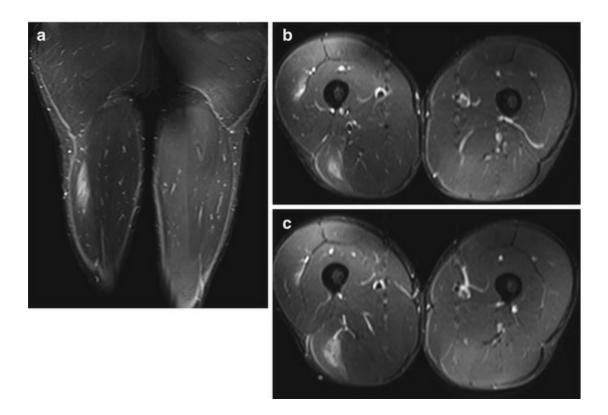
A 27-year-old male professional soccer player with proximal myotendinous junction strain. He presented with pain in the posterior thigh after a match. Coronal (a) and axial (b, c) STIR MRI show feathery intramuscular edema at the proximal myotendinous junction of the biceps femoris, consistent with a grade 1 strain
